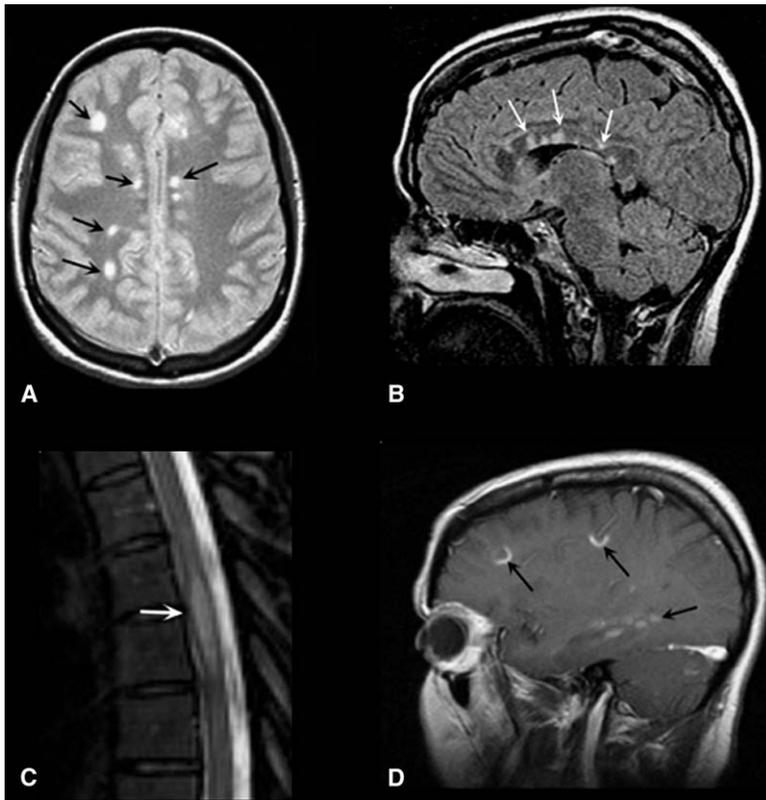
MRI Images in MS
